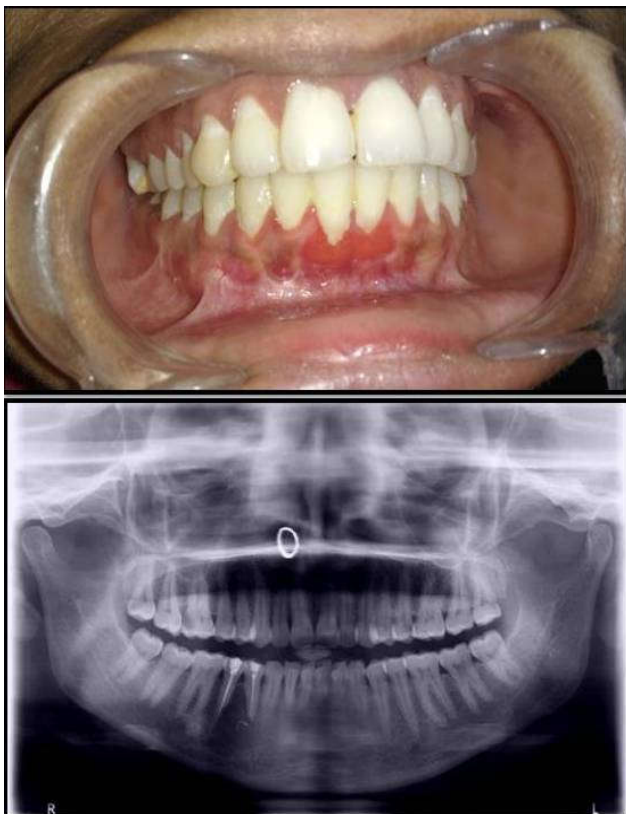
Occlusal radiograph demonstrates buccal cortical expansion in right premolar region. Panoramic radiograph revealed a single well defined, unilocular radiolucency in relation to 43-46 with presence of dense bony island in its posterior relation
